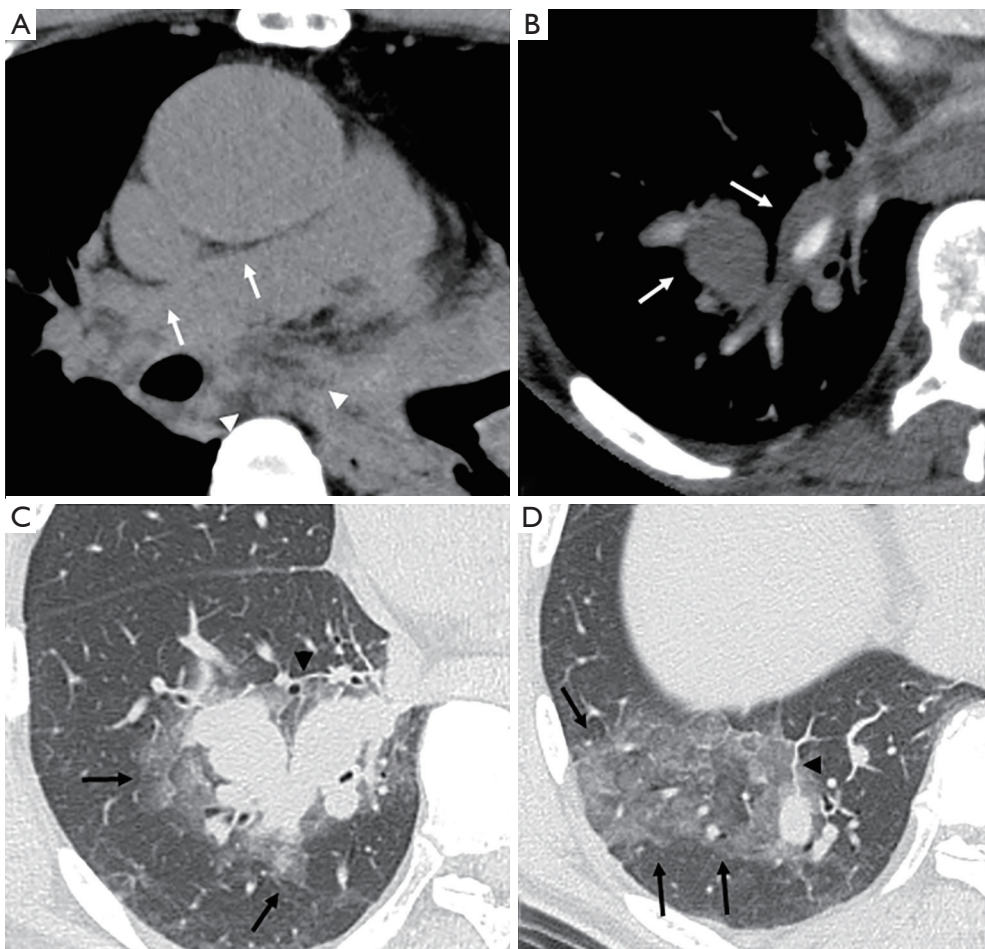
Image for a 58-year-old man with Grade 3 PAPH. (A) Non-enhanced CT showing a higher attenuation area than that of blood along the wall of the right main PA (white arrows) and mediastinal hemorrhage (white arrowheads); (B) CECT showing a thick non-contrast-enhanced area that was a suspected hematoma around the right PA in the right lung field (white arrows); (C,D) CT (lung window setting) showing thickening of the interlobular septum (black arrowheads) and extensive ground-glass opacities beyond the tissue surrounding the PA (black arrows) in the right lung field, indicating blood extending into the alveoli. PAPH, pulmonary artery periaortic hematoma; CT, computed tomography; PA, pulmonary artery; CECT, contrast-enhanced CT.
